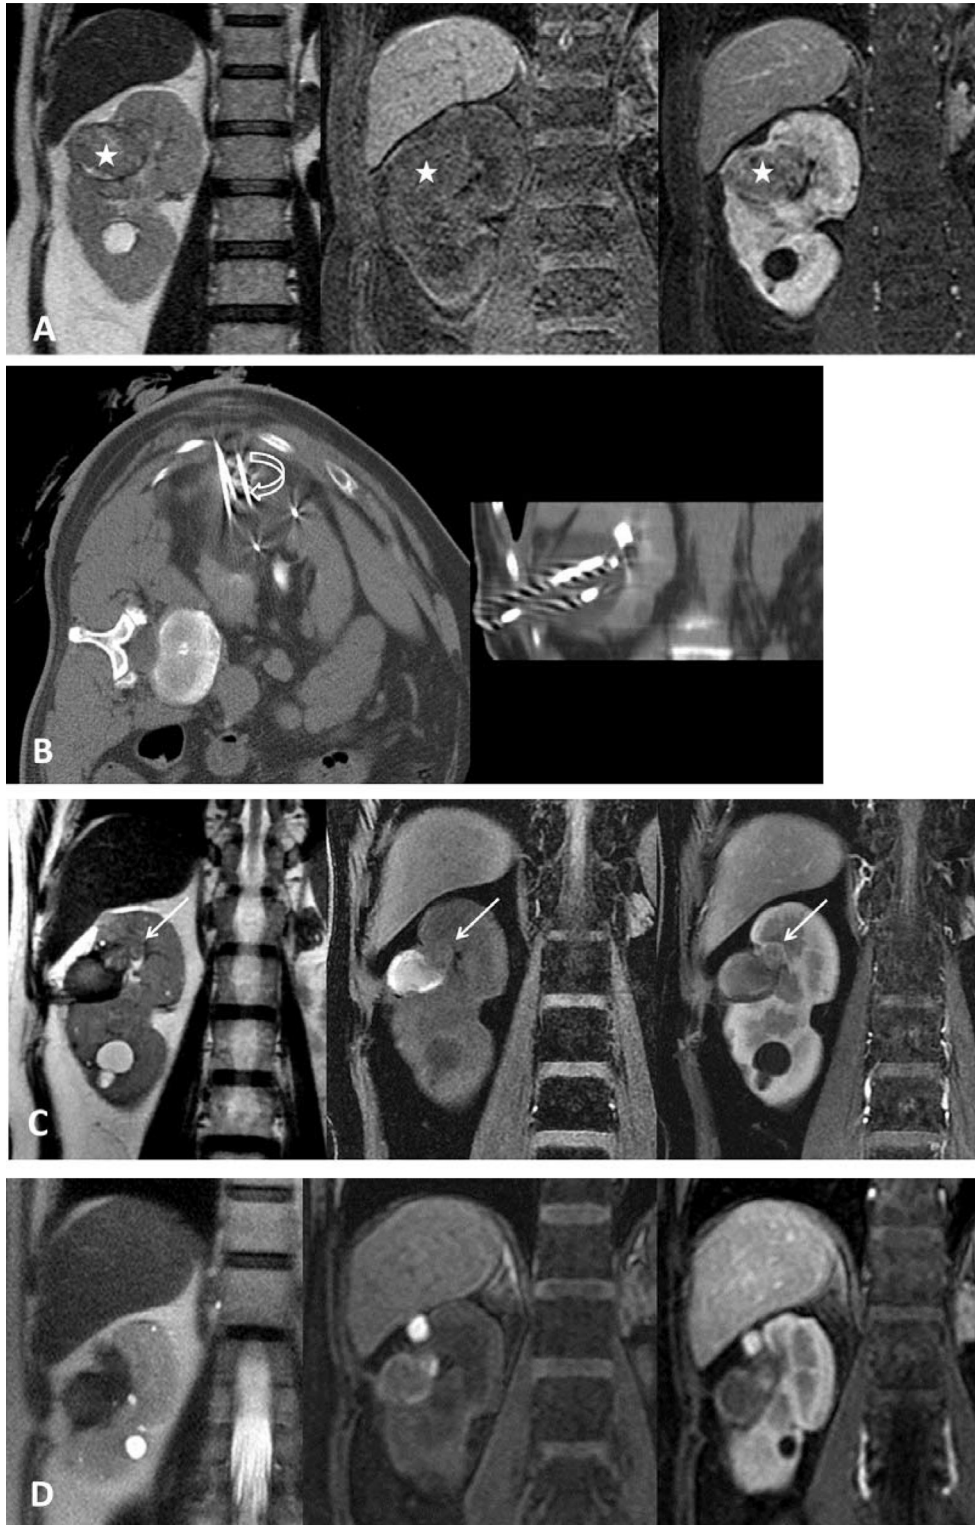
A 65-year-old male patient received left radical nephrectomy for renal cell carcinoma (RCC) 16 years ago and had a recurrent tumor in right kidney on follow-up magnetic resonance imaging (MRI). He also had other comorbidities including coagulopathy (factor VII deficiency), hypertension, arrhythmia, and chronic renal insufficiency. (A) MR scan shows a tumor at the interpolar region of the right kidney (stars), with heterogeneous signal intensity on T2-weighted imaging (left), iso signal intensity on T1-weighted imaging (middle) and modest heterogeneous enhancement on T1-weighted postcontrast enhanced imaging (right). (B) Intraprocedure CT scan during freezing (left: axial scan, right: coronal reformatted image) demonstrates multiple cryoprobes (curved arrow) and the surrounding low density area covering the tumor. (C) MR study 4 months after the procedure (from left to right: T2-weighted imaging, T1-weighted imaging, and T1-weighted postcontrast enhanced imaging) reveal recurrent tumor (arrows) at medial superior aspect of the ablated region, which shows different signal intensity and contrast enhancement in contrast to the ablated area, indicating inadequate ablation. (D) Repeat cryoablation was performed for the recurrent tumor. The MR study 9 months after the first procedure shows complete ablation of the tumor (from left to right: T2-weighted imaging, T1-weighted imaging, and T1-weighted postcontrast enhanced imaging).
